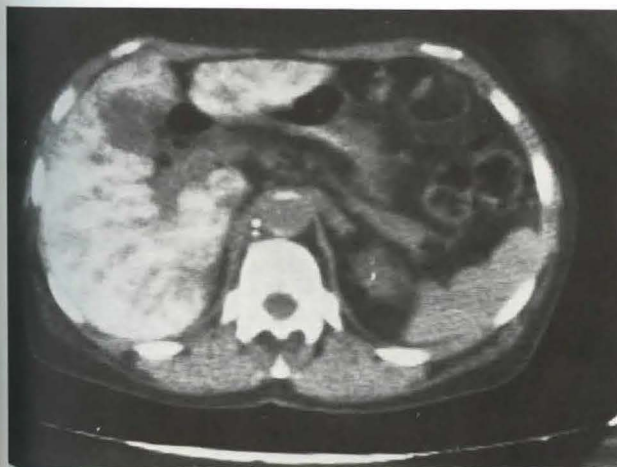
CT scan of a woman with cancer of the uterus: Lipiodol opacification of the liver in connection with large lymphatic masses creating a lymphoportal fistula
